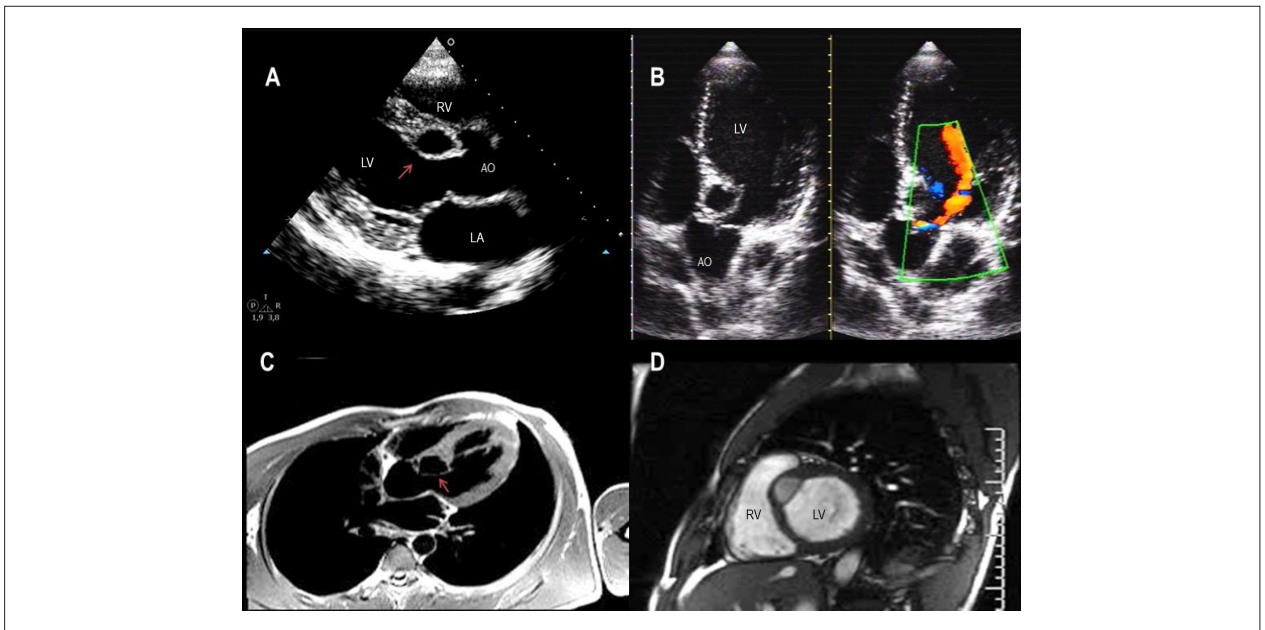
A) Transthoracic echocardiogram, parasternal longitudinal view, showing the diverticulum in the interventricular septum (arrow) adjacent to the right coronary cusp of aortic valve; B) apical five-chamber view showing the aortic regurgitant jet and apparent structural communication with the LV cavity (Doppler flow); C) Cardiac MRI, axial view in dark blood sequence, and T1-weighted image, confirms the continuity solution (arrow); D) short basal axis view sequence of cine-MRI (perfusion) shows isointense structure (muscular) and hypointense content.
